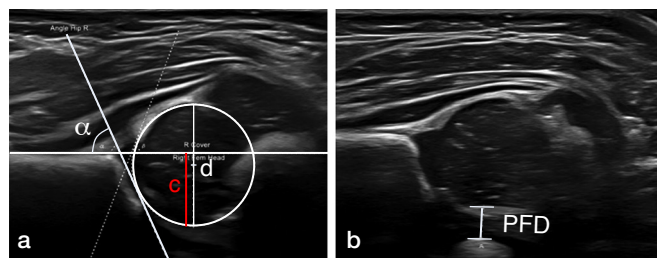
a. Ultrasound image of a newborn hip with annotated α angle and femoral head coverage (c/dx100) measurements, obtained according to the methods described by Graf [6] and Falliner [26]. b. Ultrasound image of a newborn hip with annotated PFD measurement, obtained according to the methods described by Tréguier et al. [8] but with the child in the lateral examination position.
